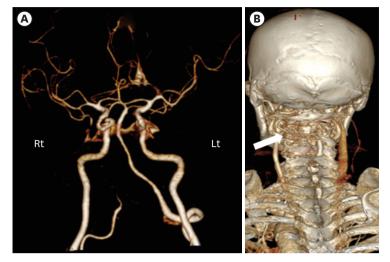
Preoperative Computed tomography angiography. (A) Computed tomography angiography showing left vertebral artery dominance. (B) A preoperative 3-dimensional reconstruction image of a computed tomographic scan of the cervical spine revealed a C2-3 osteolytic lesion (arrow).
